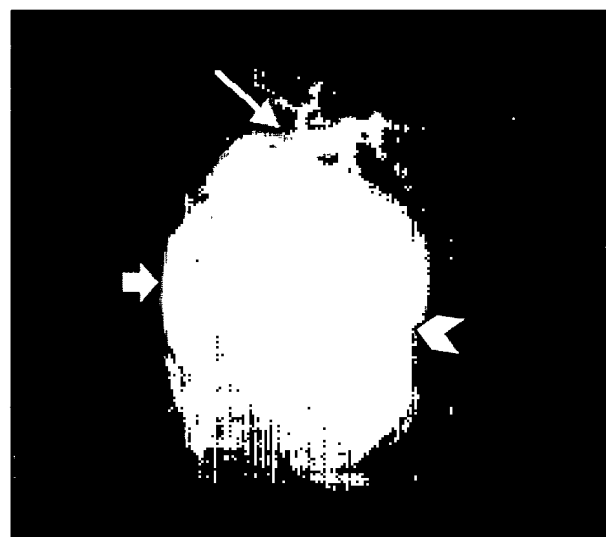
T2-weighted MRCP showed fusiform dilated common bile duct (arrow), dilated common hepatic duct (long arrow), and compressed gallbladder (short arrow)
